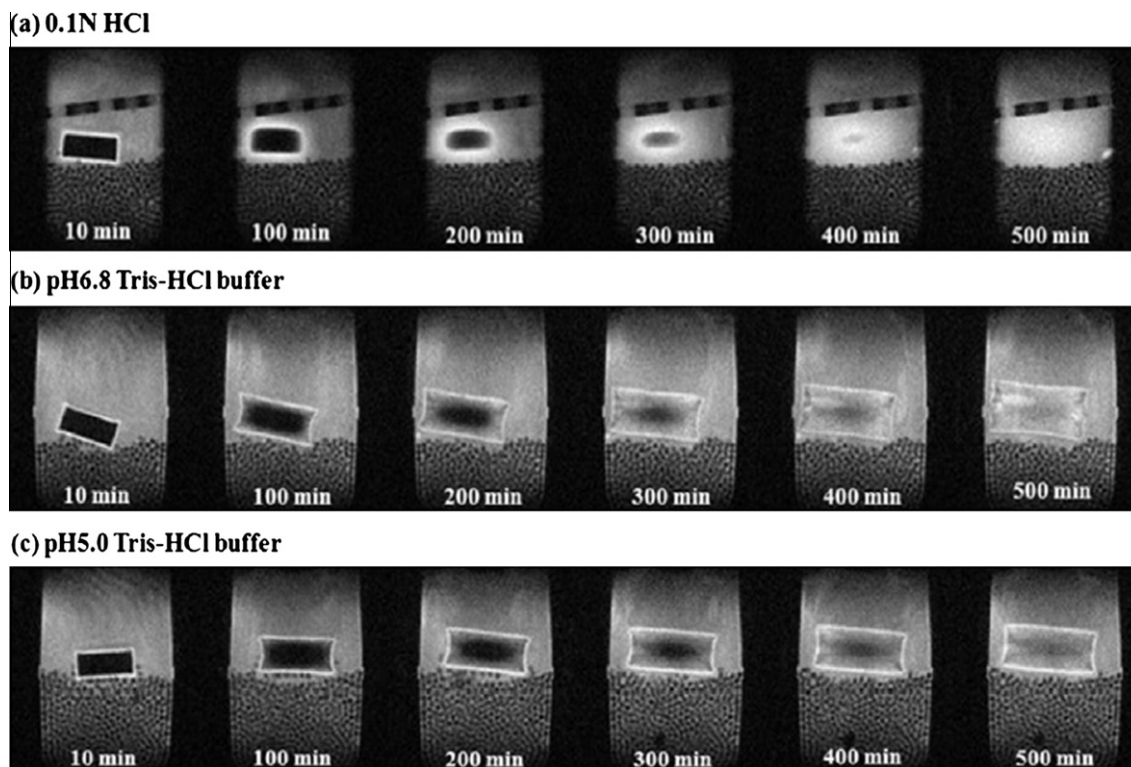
MRI images of swollen CSA tablets prepared from 45 kDa chitosan in various media: (a) 0.1 N HCl, (b) pH 6.8, and (c) pH 5.0 Tris-HCl buffers [8].
